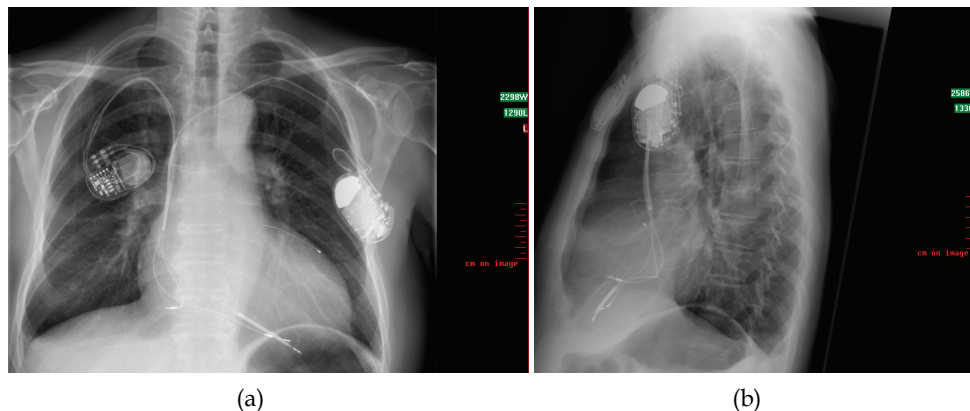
a and b. Chest x-ray PA and lateral. Implantation of a biventricular pacemaker CRT-P (Insync III 8042, Medtronic) in November 2005 in a patient with dilated cardiomyopathy. The unipolar LV-lead is positioned in an unfavoured anterolateral way. 2 years later contralateral implantation of a singular chamber ICD (Lexos VR, Biotronik) as bridge to heart transplant. The bipolar right ventricular leads were placed very close together. However, testing showed no inhibition of the ICD detecting induced ventricular fibrillation during pacemaker stimulation.
